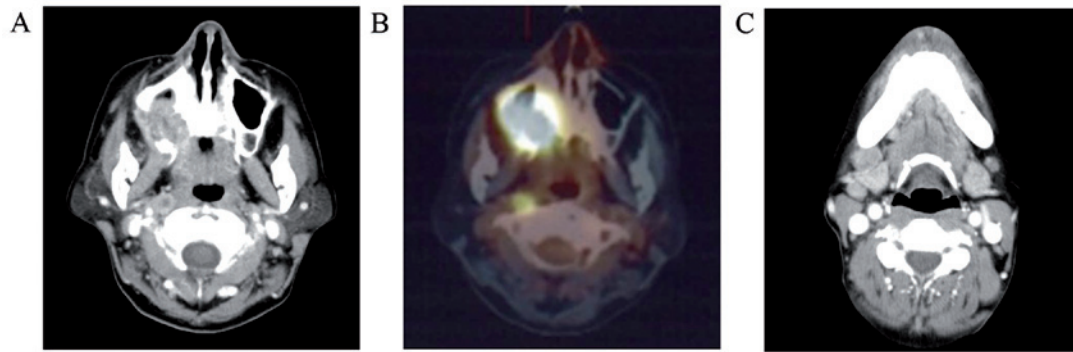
(A) Contrast CT (initial scan): The posterior part of the right maxilla is destroyed by tumor. The right LRPLN is enlarged and shows rim enhancement. (B) PET-CT finding: There is abnormal accumulation in the posterior part of the right maxilla and in the right LRPLN. (C) Contrast CT (initial scan): Metastasis to the right submandibular lymph nodes is observed. LRPLN, lateral retropharyngeal lymph node.
